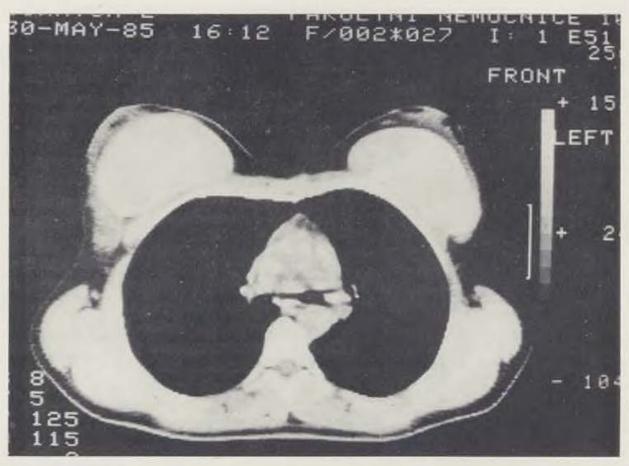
Patient M. C. CT check-up of Cronin type prostheses 5 years after implantation.
